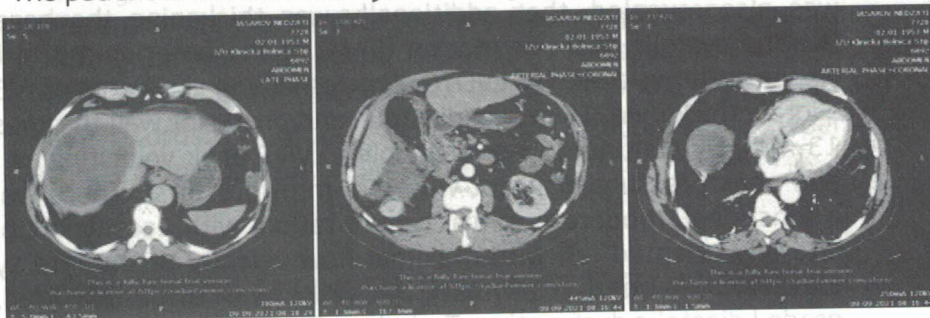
and 2 (09.09.2021). Abdominal CT with contrast (liver cyst, perforated gallbladder, and free fluid). Figure 3 (09.09.2021). Abdominal CT with contrast (Random finding of left atrial thrombus)
